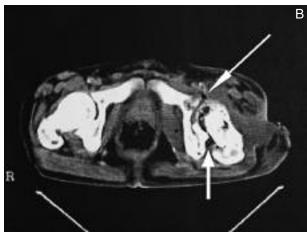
A) Preoperative abdominal CT shows inhomogenous and voluminous gluteal, iliac and psoas muscles (number 2) with drain in contact with sacroiliac joint indicating left retroperitoneal psoas abscess (number 1); B) Osteolytic changes in the roof of the left acetabulum and destruction of the femoral head and even neck with air or gas in the intraarticular (arrowhead) and posterior periarticular space (arrow) caused by the septic process.
